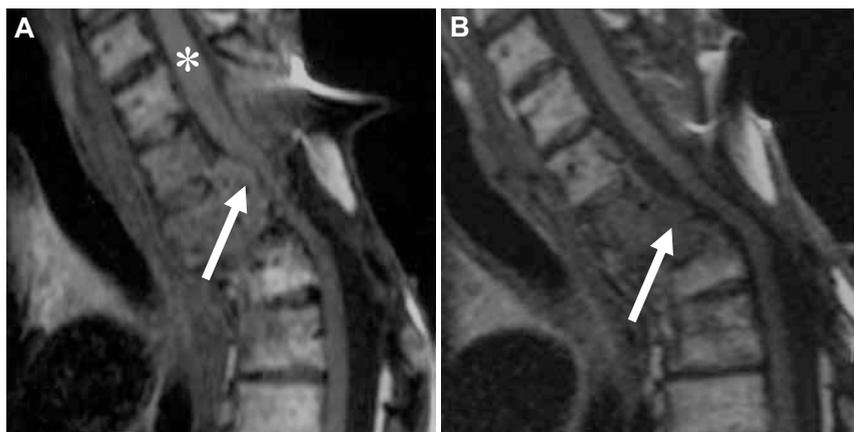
MR image (T1 weighted) of cervicothoracic spine of patient with pheochromocytoma. (A) Baseline scan 3 mo before ^{177}Lu -octreotate therapy shows tumour extending into spinal canal (arrow, *spinal cord). (B) Scan 3 mo after fourth cycle of 7.4 GBq ^{177}Lu -octreotate shows reduction in tumour extension into spinal canal (arrow).
